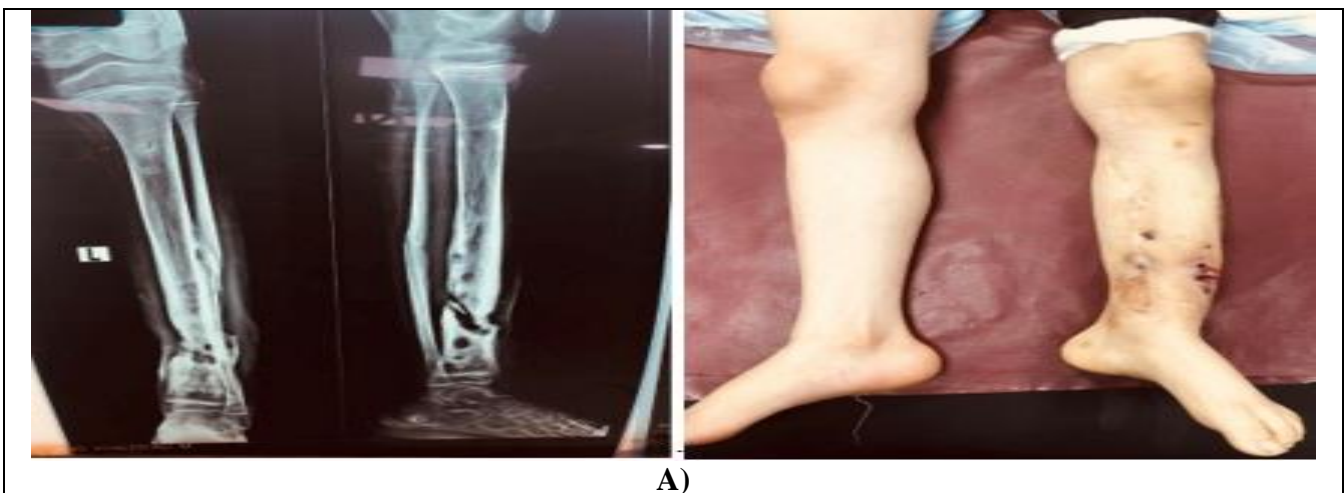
A) AP and lateral X-rays of left distal tibia infected nonunion with sequestered bone, left one clinical photo.
